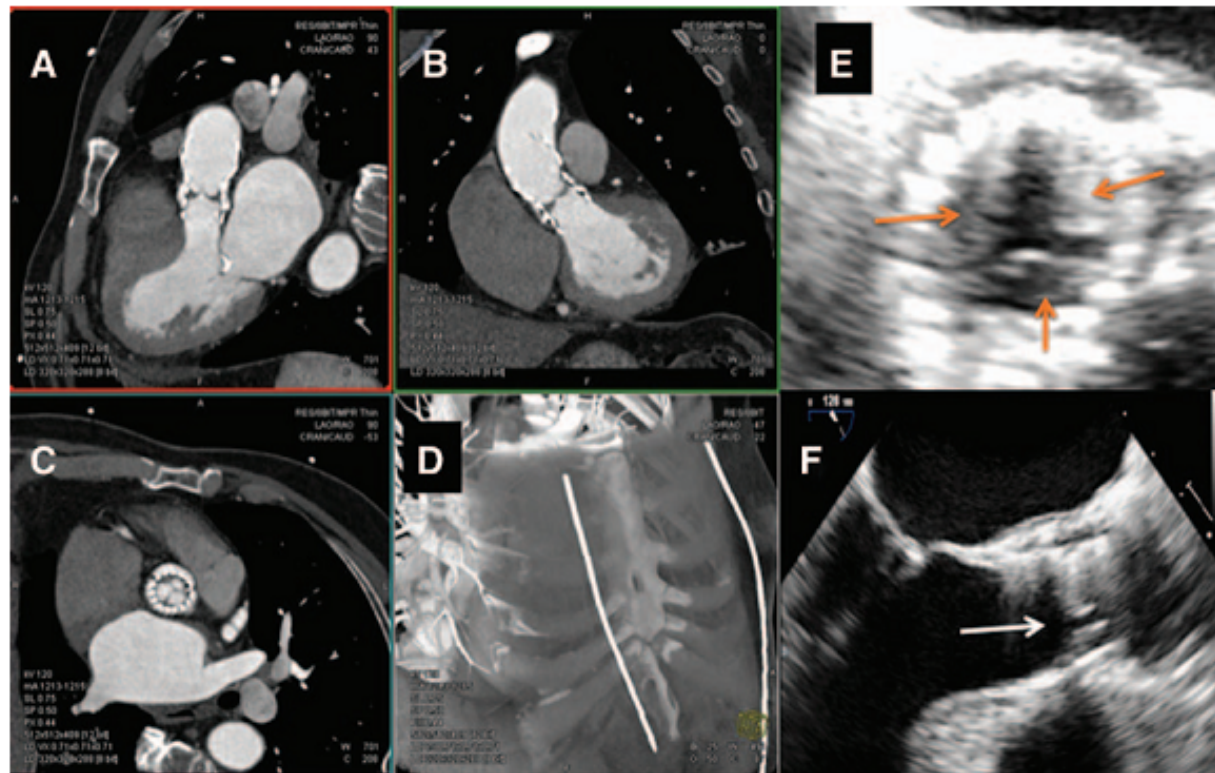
Cardiac computed tomography (CT; A–D) and transesophageal echocardiography (TOE; E–F) obtained late after CoreValve implantation showing no prosthesis displacement, no leaflet calcifications, and the absence of thrombus. Sagittal (A), coronal (B), and short-axis (C) CT views showing no prosthesis displacement and the absence of leaflet calcifications. Short- (E) and long-axis (F) TOE views showing thickened aortic cusps (arrows), no leaflet calcifications, no thrombus, limited leaflet mobility, and abnormal flow pattern across the aortic valve.
